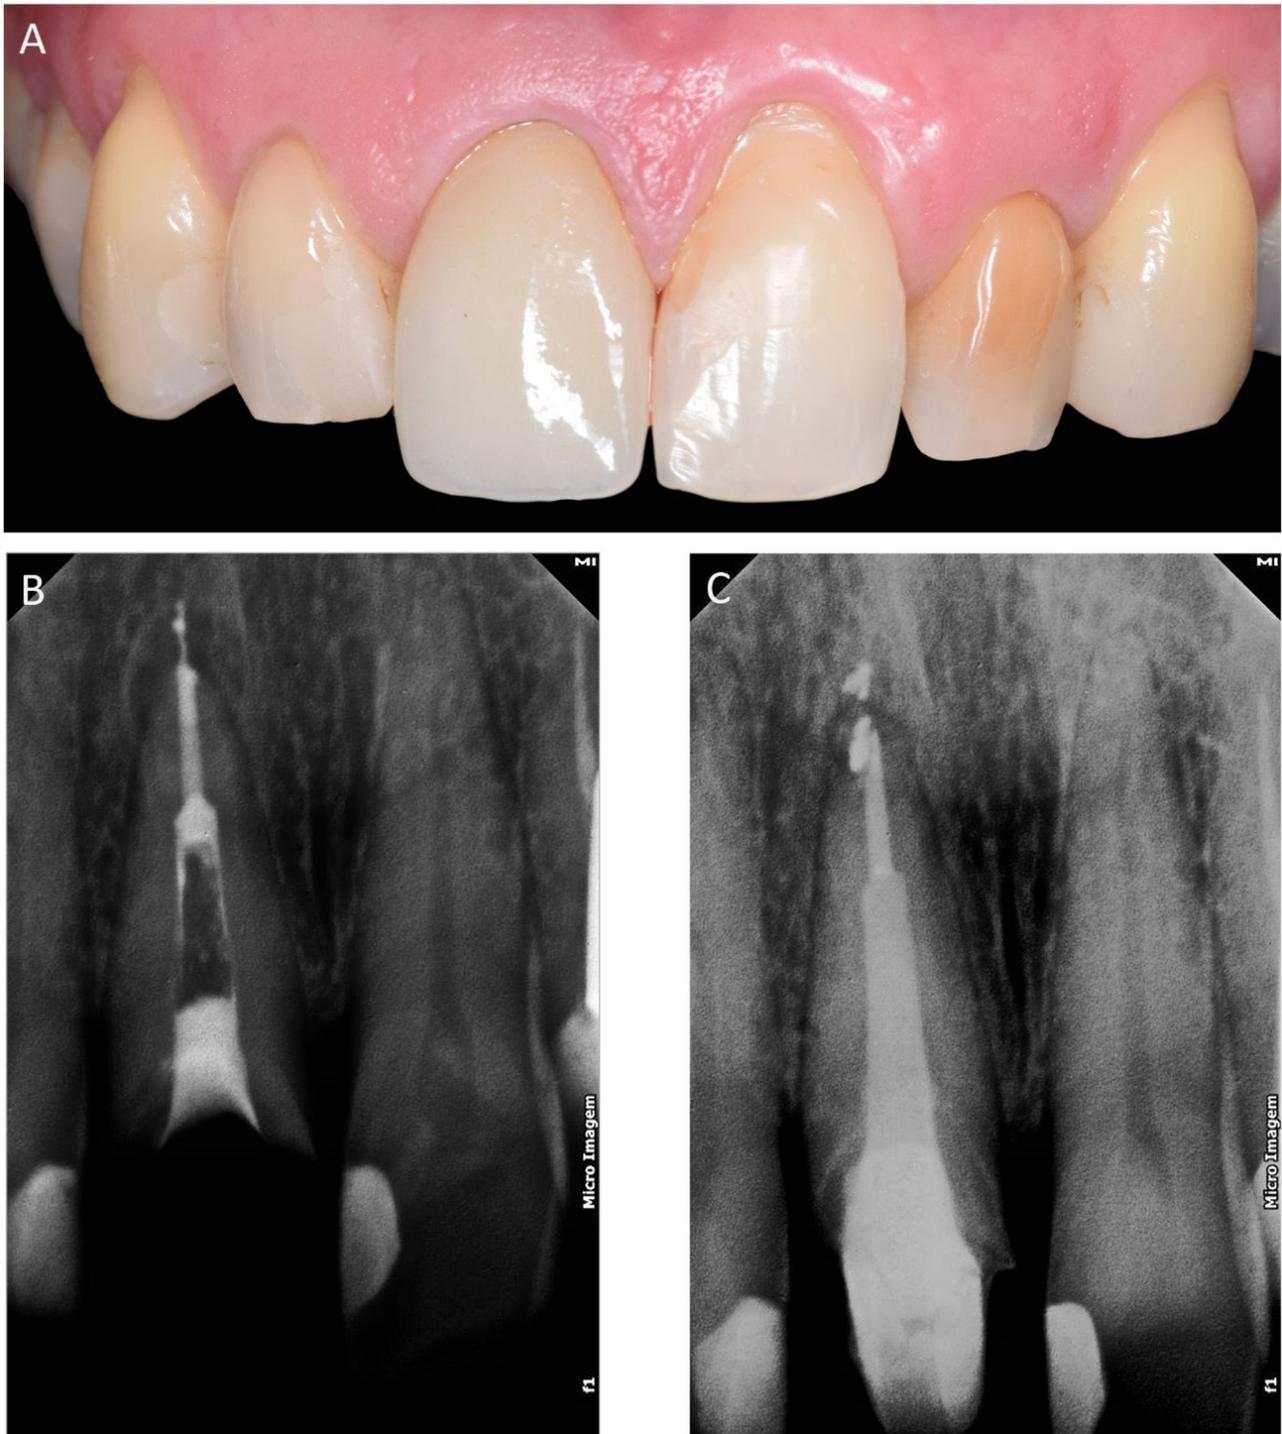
Crown cementation and follow-up sessions. (A) intraoral image immediately after the crown cementation; (B) periapical radiography immediately after the obturation; (C) periapical radiography at one-year follow-up session.
